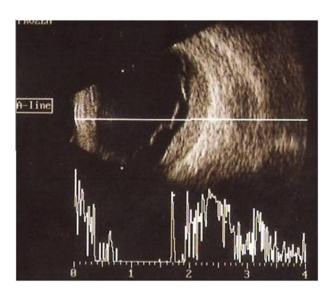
B-scan ultrasonography of a globe with choroidal metastasis shows an echogenic choroidal mass with diffuse ill defined borders and overlying retinal detachment. A-scan shows a 100% spike suggestive of retinal detachment along with moderate to high internal acoustic reflectivity of the choroidal mass.
